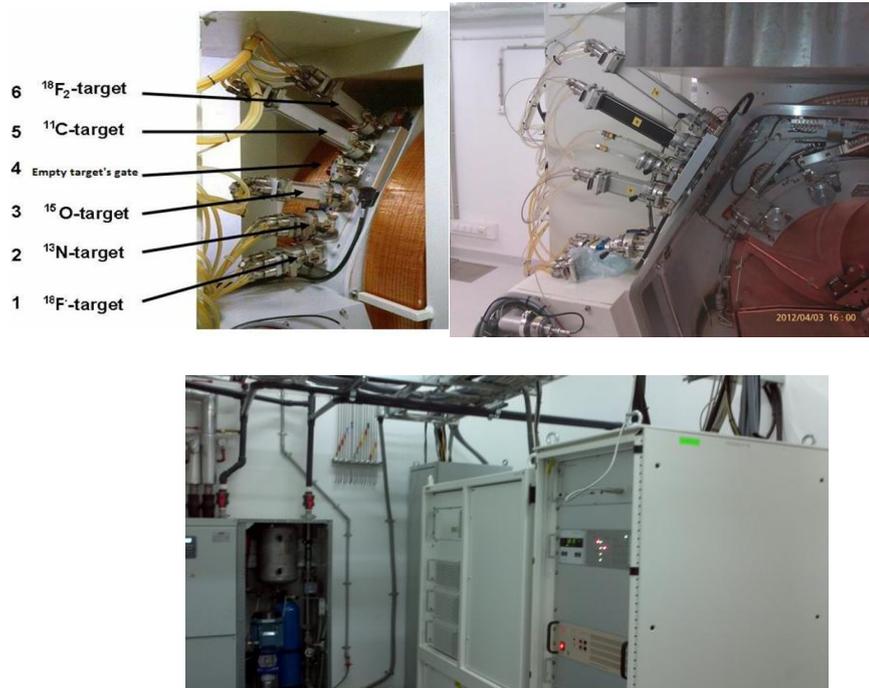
GE PETtrace 800 Cyclotron for ^{18}F -FDG Synthesis
